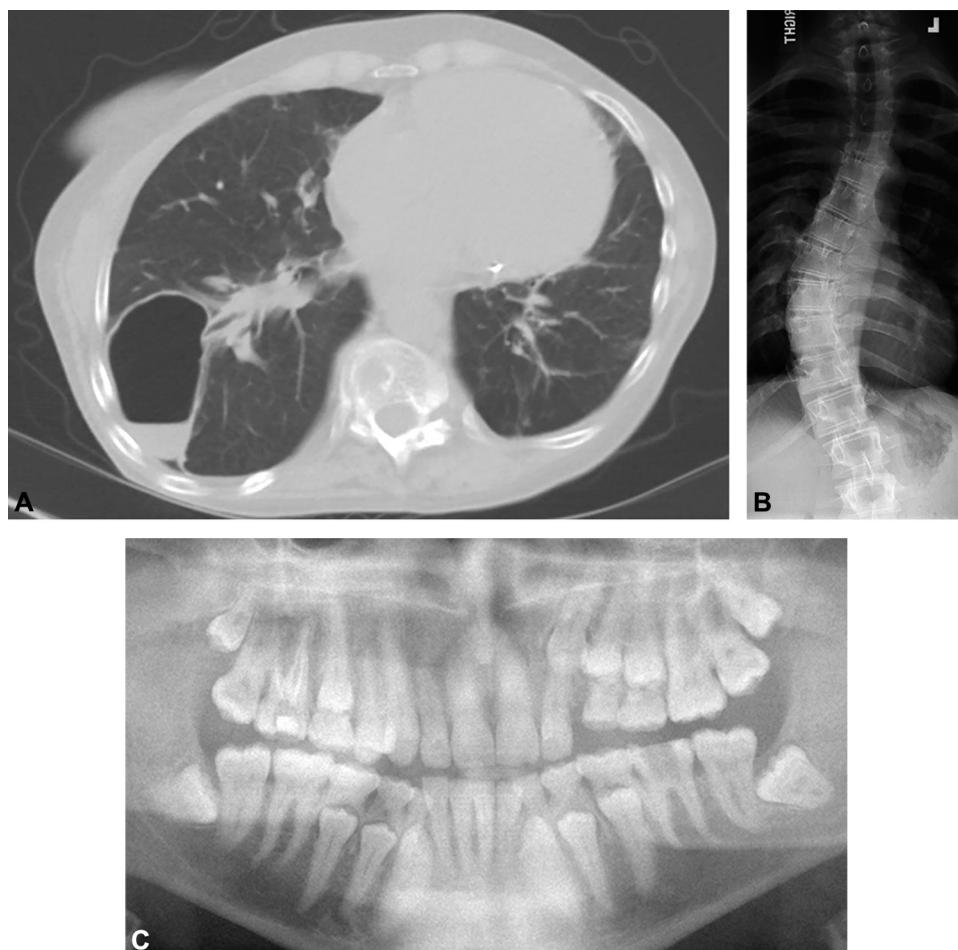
Radiographic findings of patients with autosomal dominant hyperimmunoglobulin E syndrome. A, A 42-year-old woman with right lung pneumatocele and (B) severe scoliosis. C, Multiple retained primary teeth visualized by panoramic radiograph in a 21-year-old man.
